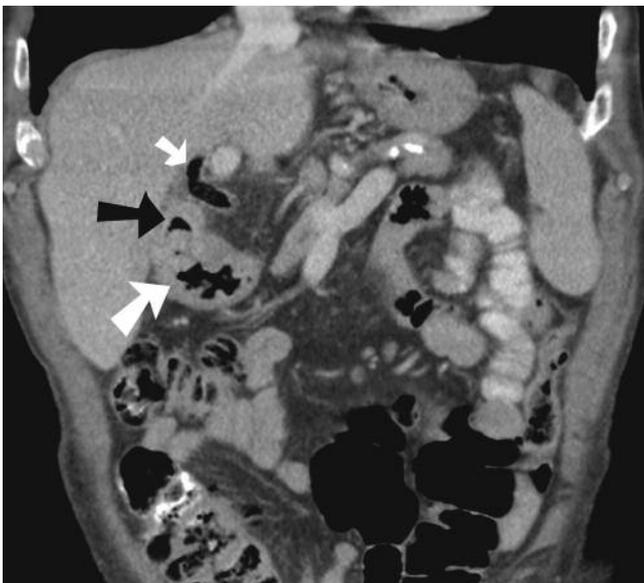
Coronal reformatted contrast-enhanced CT showing air within the common bile duct (small white arrow). Air is also demonstrated within the gallbladder, which is thick walled (black arrow) and fistulating directly into the adjacent gastric antrum (large white arrow).
